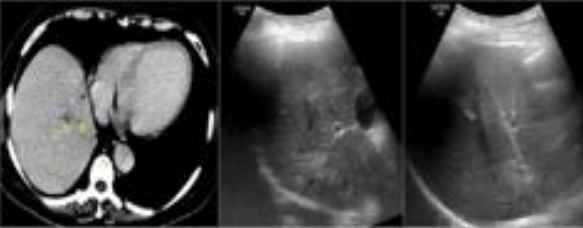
69 Y / Male, operated case of carcinoma colon, on observation. Surveillance CT scan shows an irregular hypodense lesion in right lobe of liver (black arrow in a) and associated focal IHBR dilatation (yellow arrow in a). Correlative ultrasound shows an irregular hyperechoic lesion in right lobe of liver (black arrow in b). USG guided FNAC was done (c) with needle close to the branch of portal vein (white arrow in c) and is avoided.
